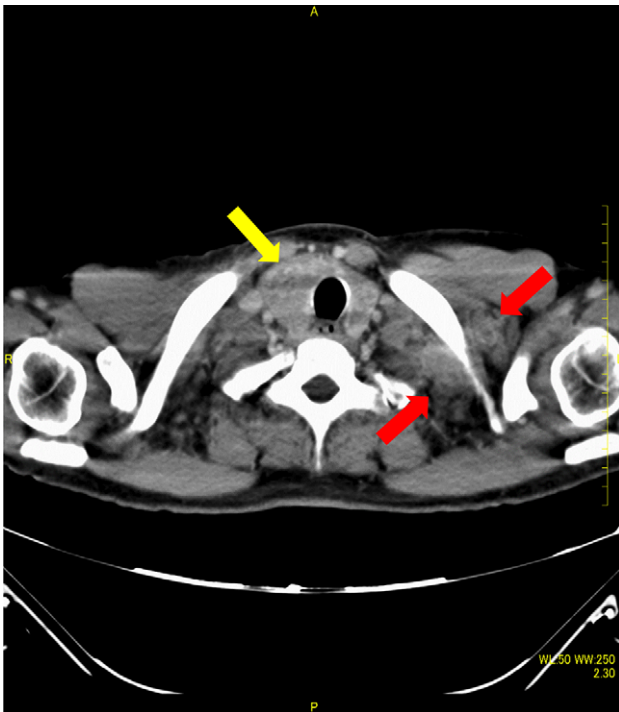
Contrast-enhanced CT scan showing the thyroid tumour (yellow arrow) and subcutaneous nodules/tumours in the left supraclavicular region (red arrows). The thyroid gland and lymph nodes were enlarged in the neck and shoulders.
